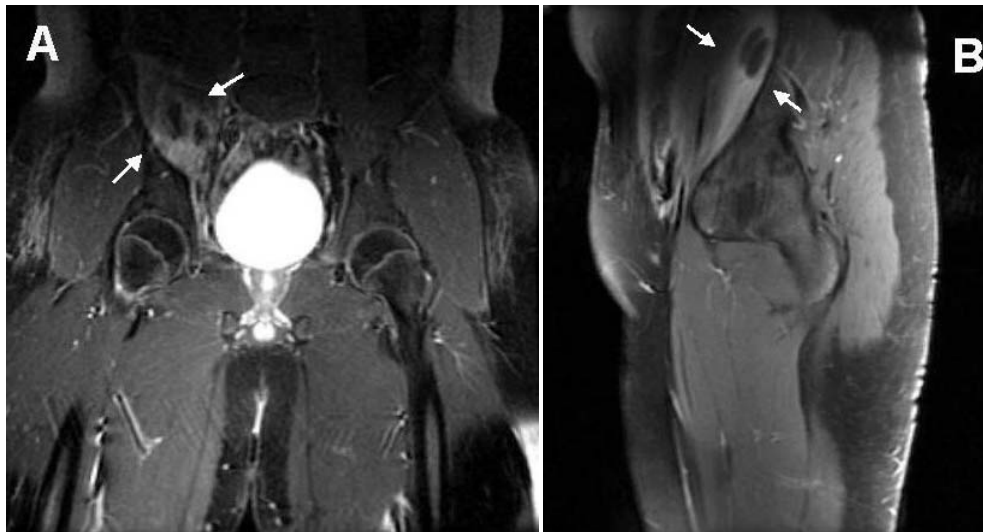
Magnetic resonance imaging of the hip (enhanced) showing swelling of the right psoas muscle with heterogeneous enhancement and multifocal non-enhanced abscesses of approximately 3×1.5 cm (arrows). The MRI is consistent with cellulitis and abscess in the right iliopsoas muscle and associated inflammatory changes in the adjacent presacral fat plane. (A) coronal image, (B) sagittal image.
